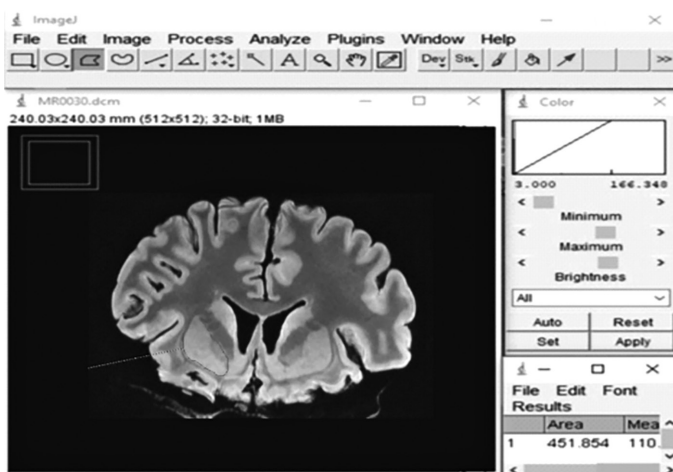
Evaluation of MR image in J image analysis program. MR, magnetic resonance.
